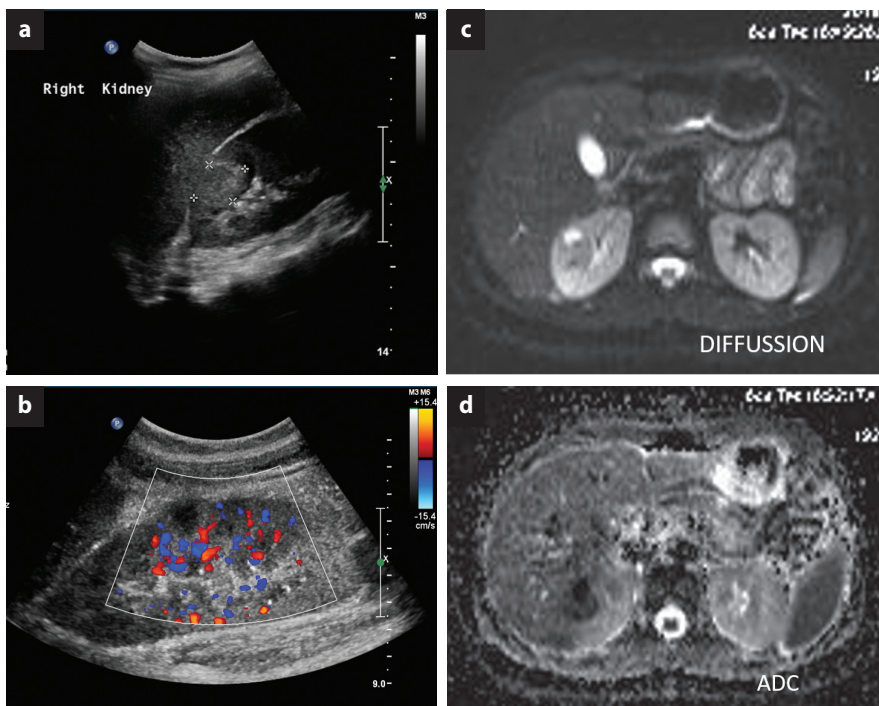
(a-b). Patient #1. Ultrasound images, grayscale (a) and color doppler (b) show a well-defined inhomogeneously hypoechoic lesion, (largest dimension 1.5cm) within the renal cortex which has a more hypoechoic center. On color Doppler the lesion is hypovascular with only peripheral vascularity (b).
